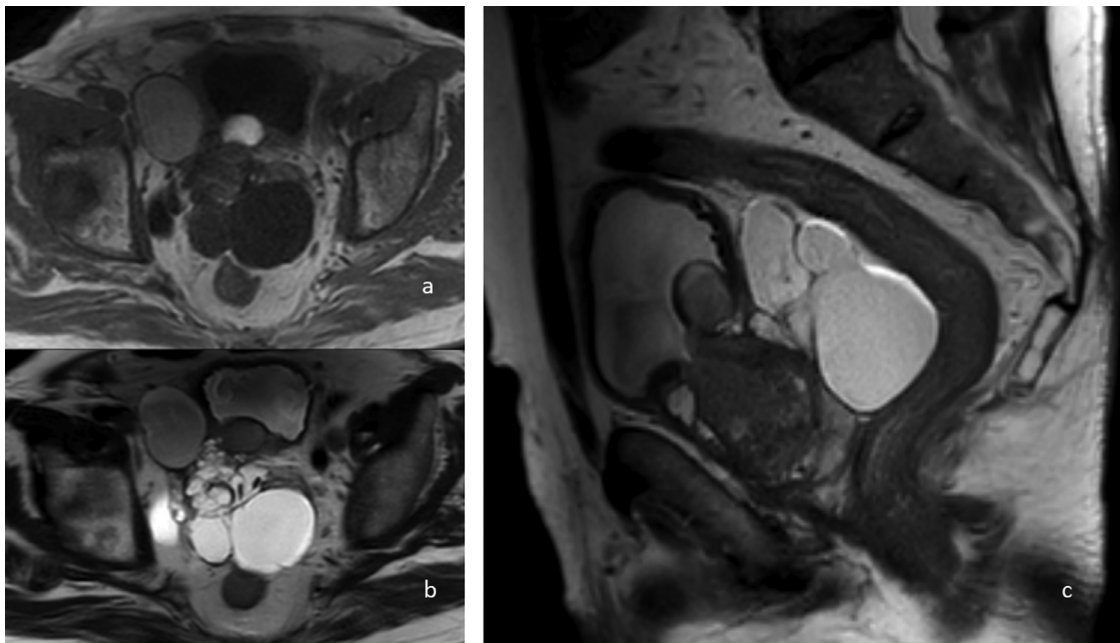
Multi-parametric Magnetic Resonance Imaging (mpMRI) of the pelvis (prostate protocol) of various sequences. (A) Axial view of a T1-weighted image showing innumerable number of homogenous and heterogeneous cysts arising from the prostate, the largest measuring 40 × 51 mm, just anterior to the rectal wall. The bladder is seen collapsed and pushed laterally. (B) Axial view of a T2-weighted image showing again nearness of the cysts to the rectum posteriorly. (C) Sagittal view of a T2-weighted image showing the mass abutting on the rectum posteriorly.
